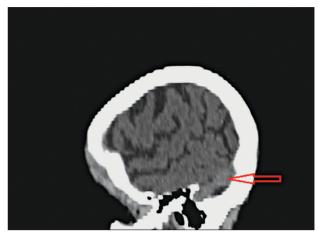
Non-contrast CT scan sagittal reformatted images at the level of distal transverse sinus. A) A positive VAS is demonstrated in a patient known to have IIH proved by lumbar puncture. Note the sinus is thin with straight upper and lower borders (red arrow). B) Normal sinus appearance in a control patient with normal CSF pressure on lumbar puncture. The sinus has an appreciable luminal diameter with concave borders (red arrow).
